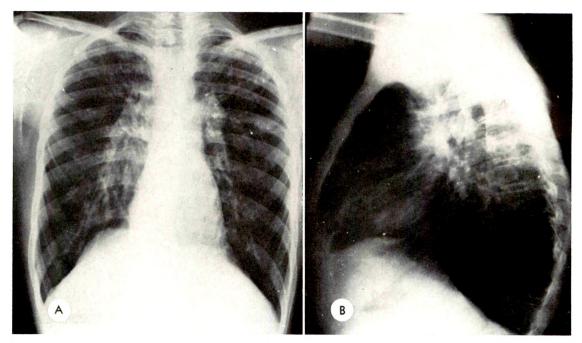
(A and B) Survival into maturity. Chest roentgenograms of a male, aged 22 years, with severe emphysema and limited pulmonary function.
